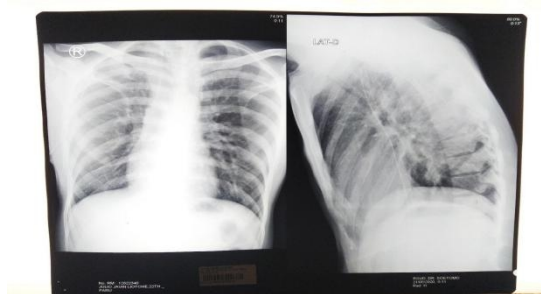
Chest X-ray after chest tube installation, the lungs appear to have expanded, and the right lung infiltrates are obtained
